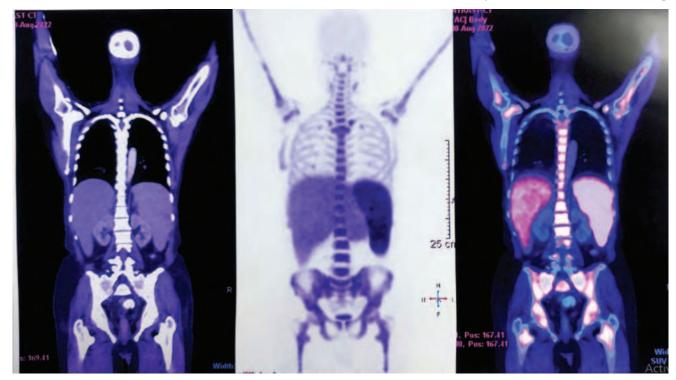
CT, PET and PET-CT image of 59-Yr old male with Bone Liver Spleen subtype of Diffuse Large B Cell Lymphoma showing hepatosplenomegaly with diffusely increased FDG uptake in liver spleen and bone marrow of axial and appendicular skeleton. No significant lymphadenopathy was noted.
